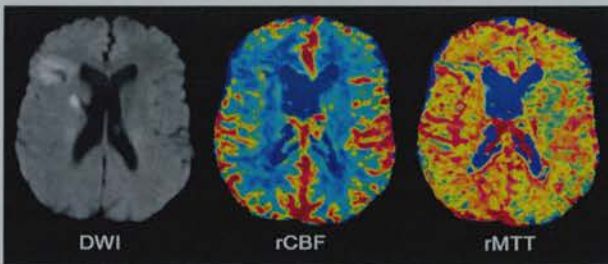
A patient with a matched PI and DWI deficit
